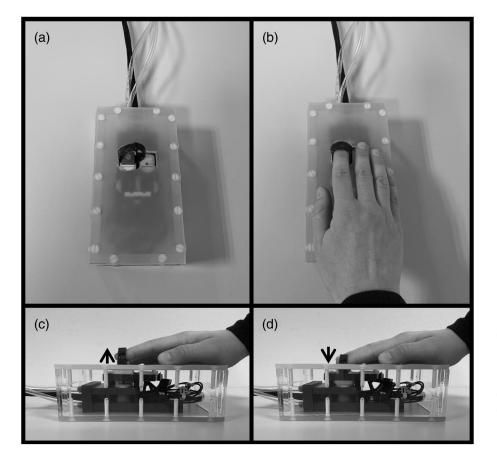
Custom-made MRcompatible pneumatic passive button device. (a,b) Subjects placed their right index finger on the button device. During the experiment, the button could be actively pressed by the subjects, or it was pulled down passively by compressed air. (c) A movement started with the button in the upper position. (d) When the button was moved to the lowest position, the stimulus presentation was triggered, either with or without a delay. disentangle recalibration effects arising due to changes in sensorimotor predictions from those due to changes in intersensory timing. To ensure that subjects' fingers followed the button movement smoothly during passive conditions, they were tied to the button by using an elastic fabric band. During the movements, optic fibers allowed for the tracking of the button position by custom-written software. Thereby, visual or auditory stimuli could be displayed at the end of a button press movement (i.e., when the button reached the lowest position) with high temporal accuracy with or without an additional delay. The visual stimulus was a Gabor patch (1-degree visual angle, spatial frequency: 2 cycles/degree), which appeared at the center of a monitor (refresh rate: 60 Hz). The monitor was located behind the MRI scanner and subjects could see it through a mirror mounted on the head coil. The auditory stimulus was a sine-wave tone (2000 Hz with 2 ms rise and fall) and was presented through MR-compatible headphones (MR-Confon Optime1, Magdeburg, Germany). Visual and auditory stimuli were presented for a duration of 33.4 ms each.
